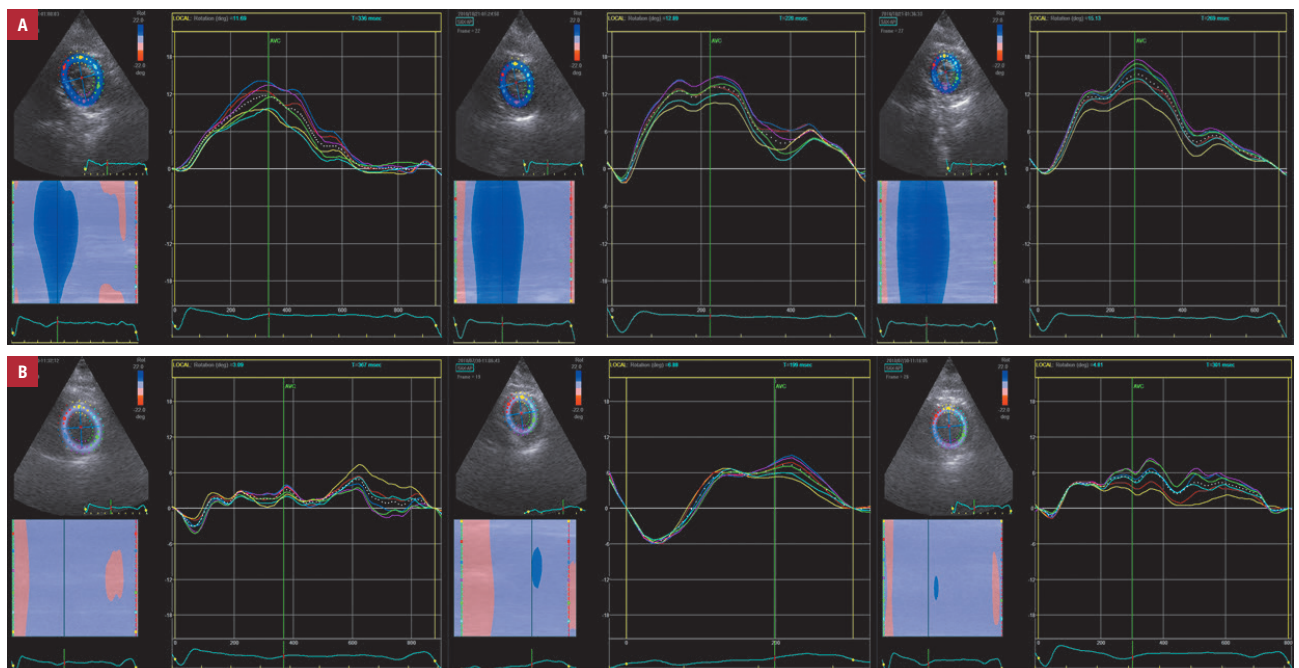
Apical rotation at rest, at peak stage, and at recovery stage of dobutamine stress echocardiography: A – patients with coronary artery disease (CAD); B – patients without CAD
